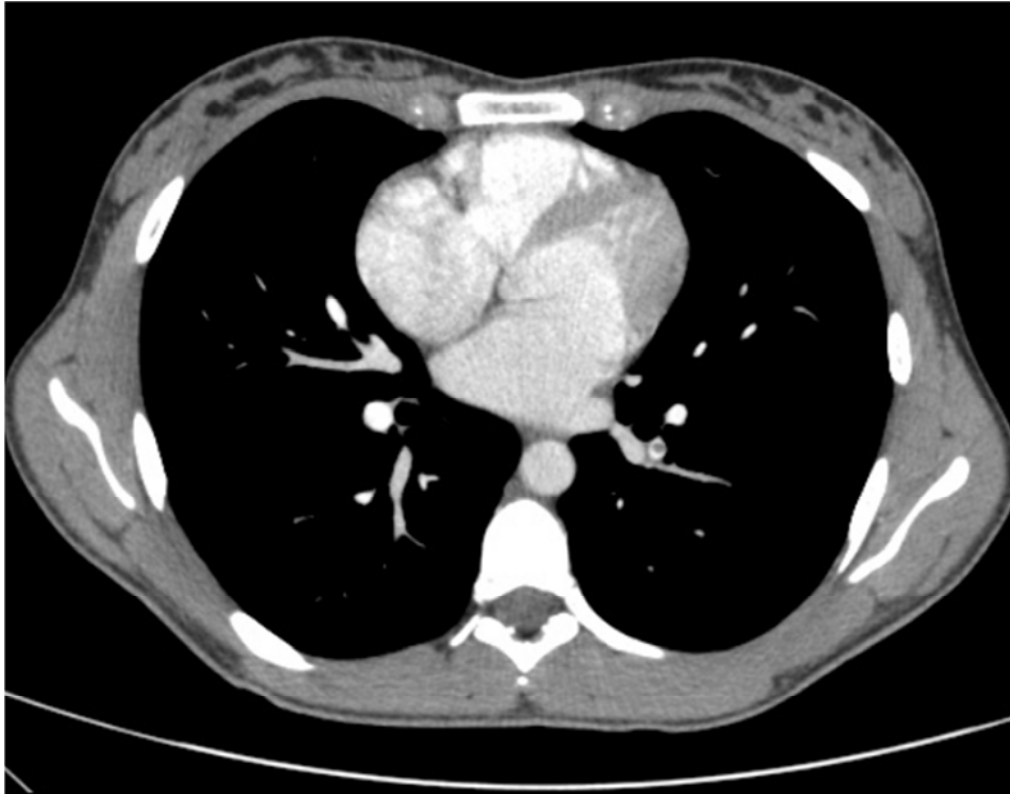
Computed tomographic angiography of chest demonstrating filling defects in axial plane.
